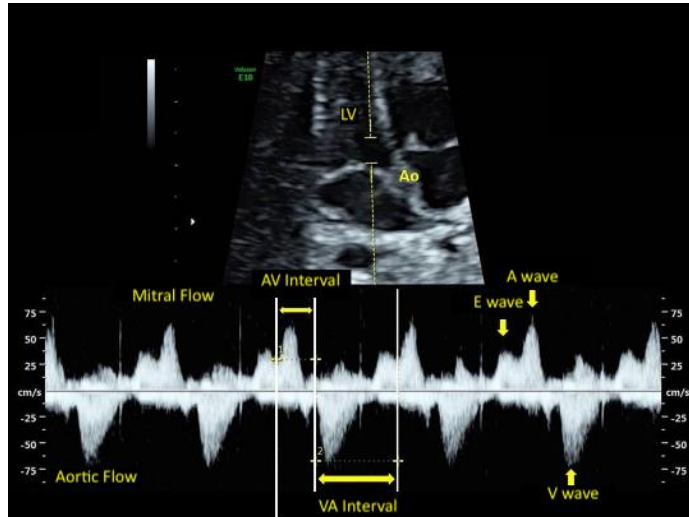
Mitro-aortic pulsed Doppler. Identification of mitral E and A waves and aortic V wave. The AV interval is measured from the beginning of the A wave to the beginning of the V wave. The complementary interval is the VA interval.
